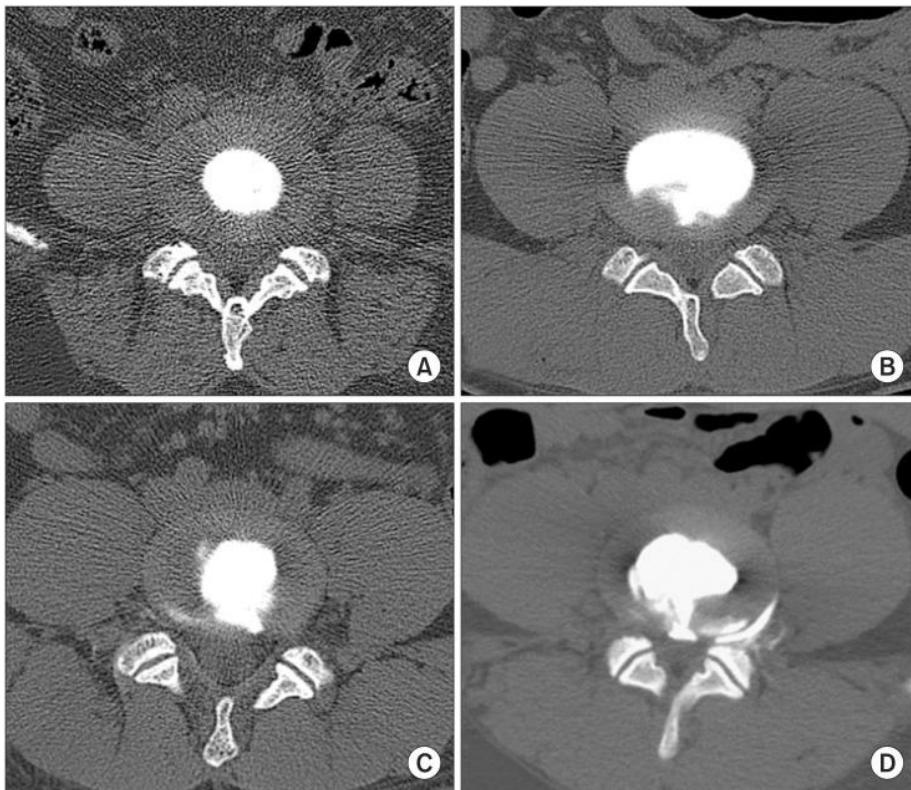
Axial view of IVDs seen on CT discogram. The contrast agent is visible in white within the intervertebral disc (A-D) and also outside the peripheral intervertebral disc (D), displaying the distribution of injected contrast agent and, thus, the extent of fissuring. The annular disruption is categorized according to Dallas discogram description as follows; (A) Grade 0, (B) Grade 1, (C) Grade 2, (D) Grade 3.
